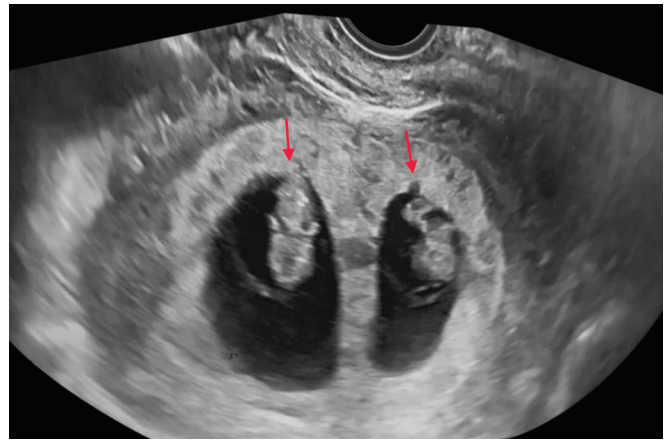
Transvaginal sonography showing intrauterine dichorionic diamniotic twin pregnancy
